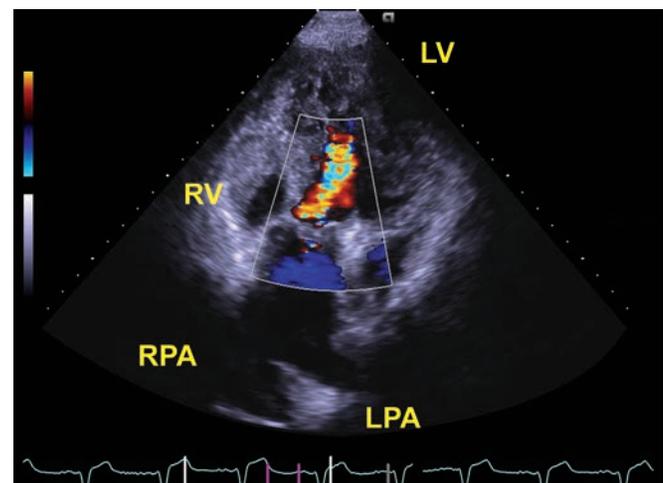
Apical five chamber view. The vessel arising from the left ventricle is the pulmonary artery, because it bifurcates into its two branches (LPA and RPA). Pulmonary regurgitation was also noted. The pulmonary artery arises rightward and posterior to the aorta (D-transposition of great arteries).
